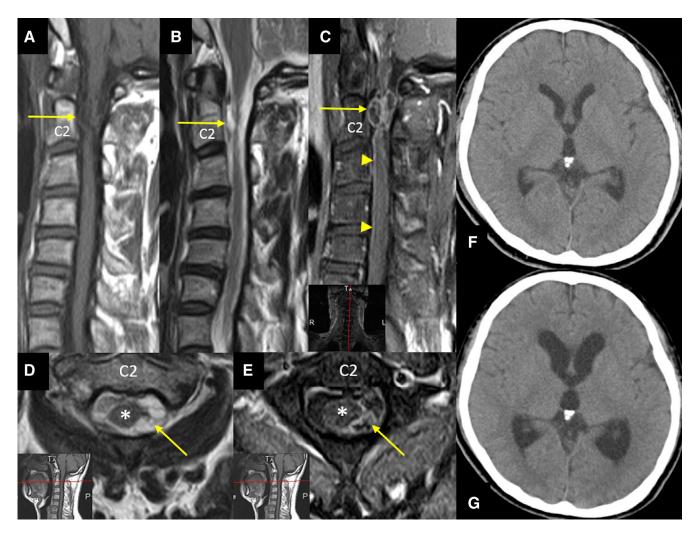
Sagittal T1- (A), sagittal and axial T2-weighted (B, D), postcontrast sagittal (C), and axial (E) magnetic resonance images showing a heterogeneously enhancing, polycystic intradural mass at C2, occupying the left dorsolateral part of the spinal canal (A-E, arrow). Rim-like enhancement is found along the surfaces of the spinal cord (C, arrowheads). Asterisk: cord. (F, G) Cranial computed tomography scans of the same level taken at presentation (F) and 20 days later showing the presence of ventriculomegaly (G).
